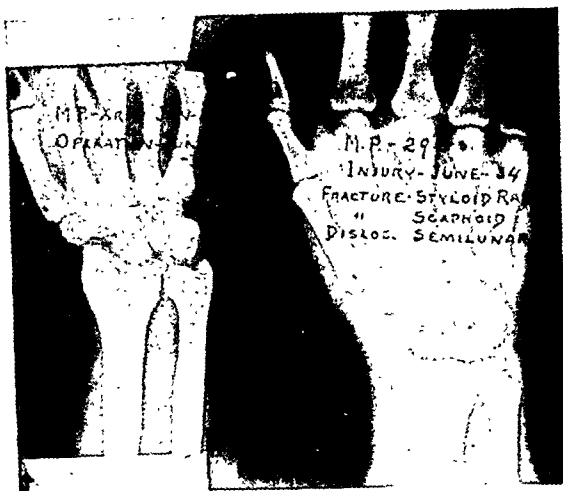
X-ray photographs of wrist in which dislocation of the semi-lunar, fracture of the scaphoid and of the radial styloid was treated by resection of the two carpal bones. This man recently examined showed slight disability only.
